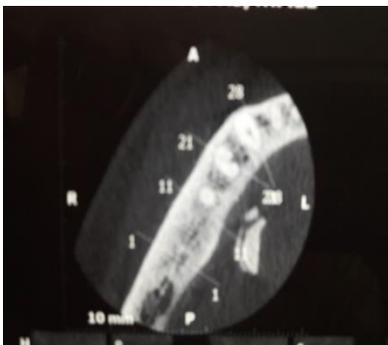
CBCT showing high density area
